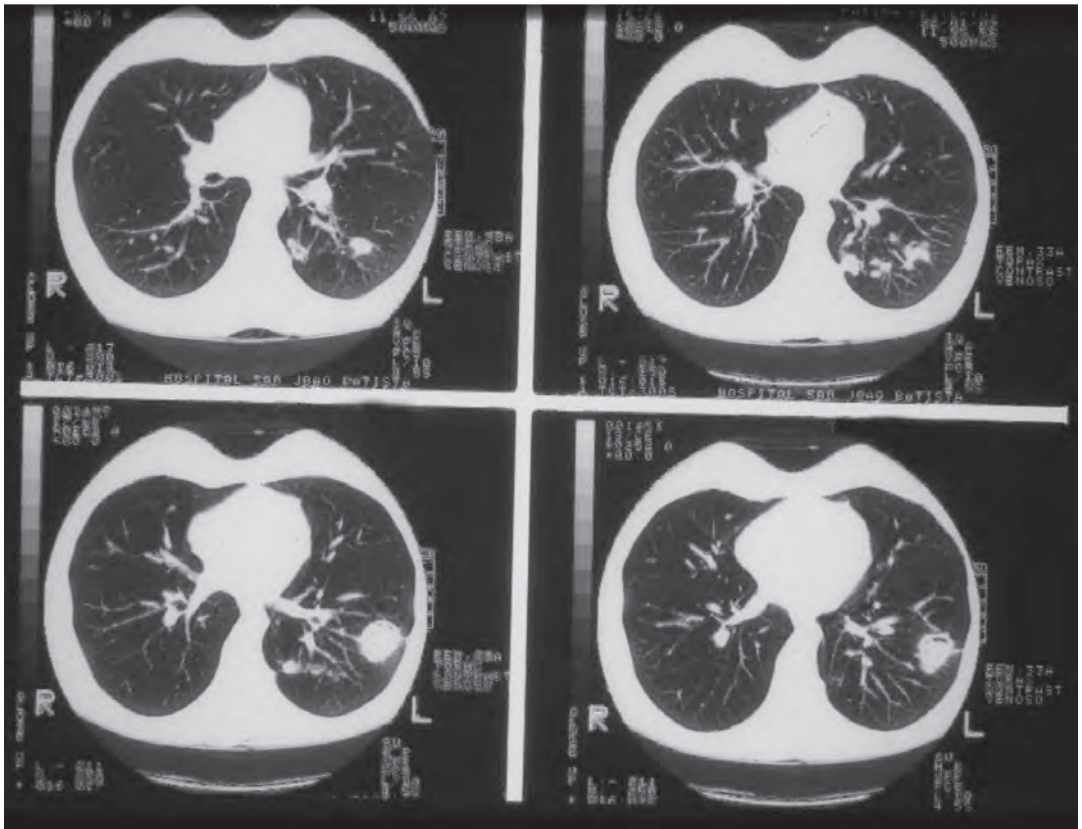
Pulmonary histoplasmosis in a 29-year-old female patient with a history of melanoma and treatment with antineoplastic agents (patient 5). The CT scans reveal multiple, sharply circumscribed, randomly distributed nodules, predominantly in the left lung.
